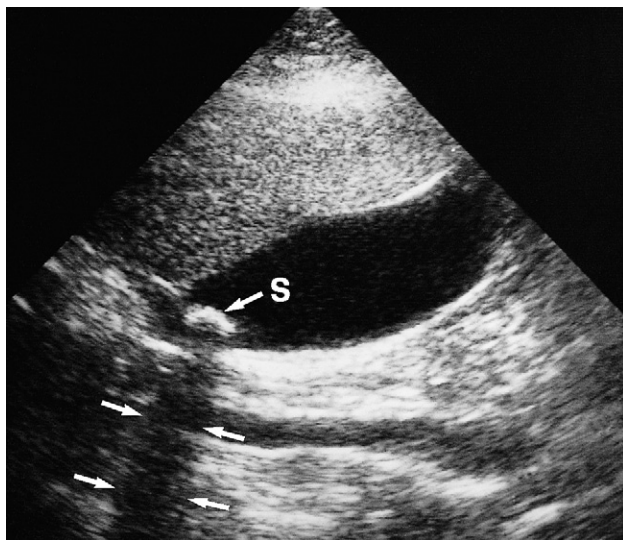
Ultrasound of a gall stone showing a stone (S) in the gall bladder. The arrows point to the acoustic shadow behind the stone.
